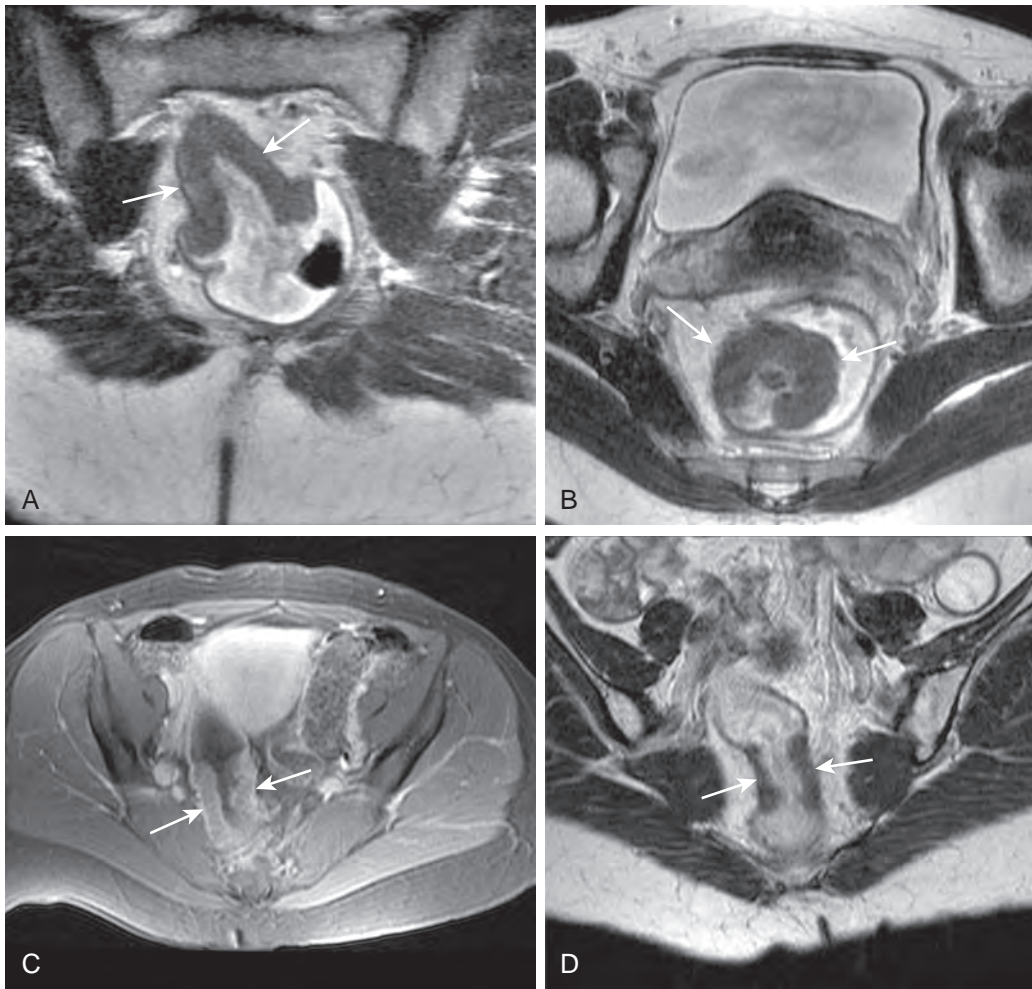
Rectal cancer. Coronal (A) and axial (B) surface coil, T2-weighted MR images angled parallel and perpendicular to rectal cancer depict a T3 rectal cancer (arrows) with extramural tumor extension. C. Axial gadolinium-enhanced SGE image shows the irregular rectal mass (arrows). D. Follow-up MRI scan obtained after chemotherapy shows response to treatment, with marked decrease in the rectal cancer (arrows).
